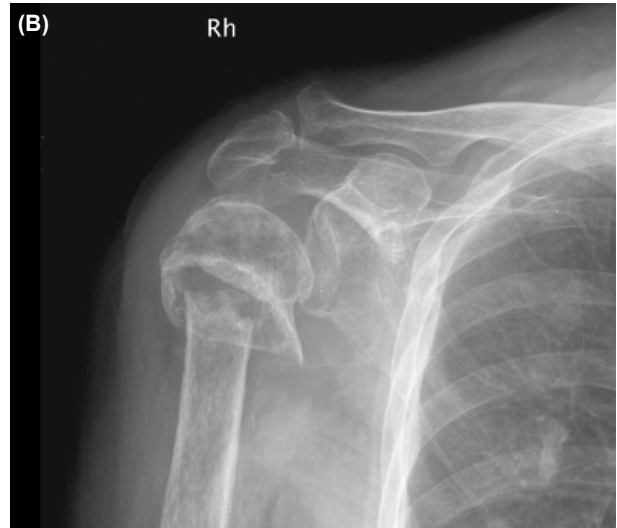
Anteroposterior radiograph of right shoulder joint with shoulder joint in (A) internal rotation (B) external rotation showing deficient bone stock with humeral head cavitation.
